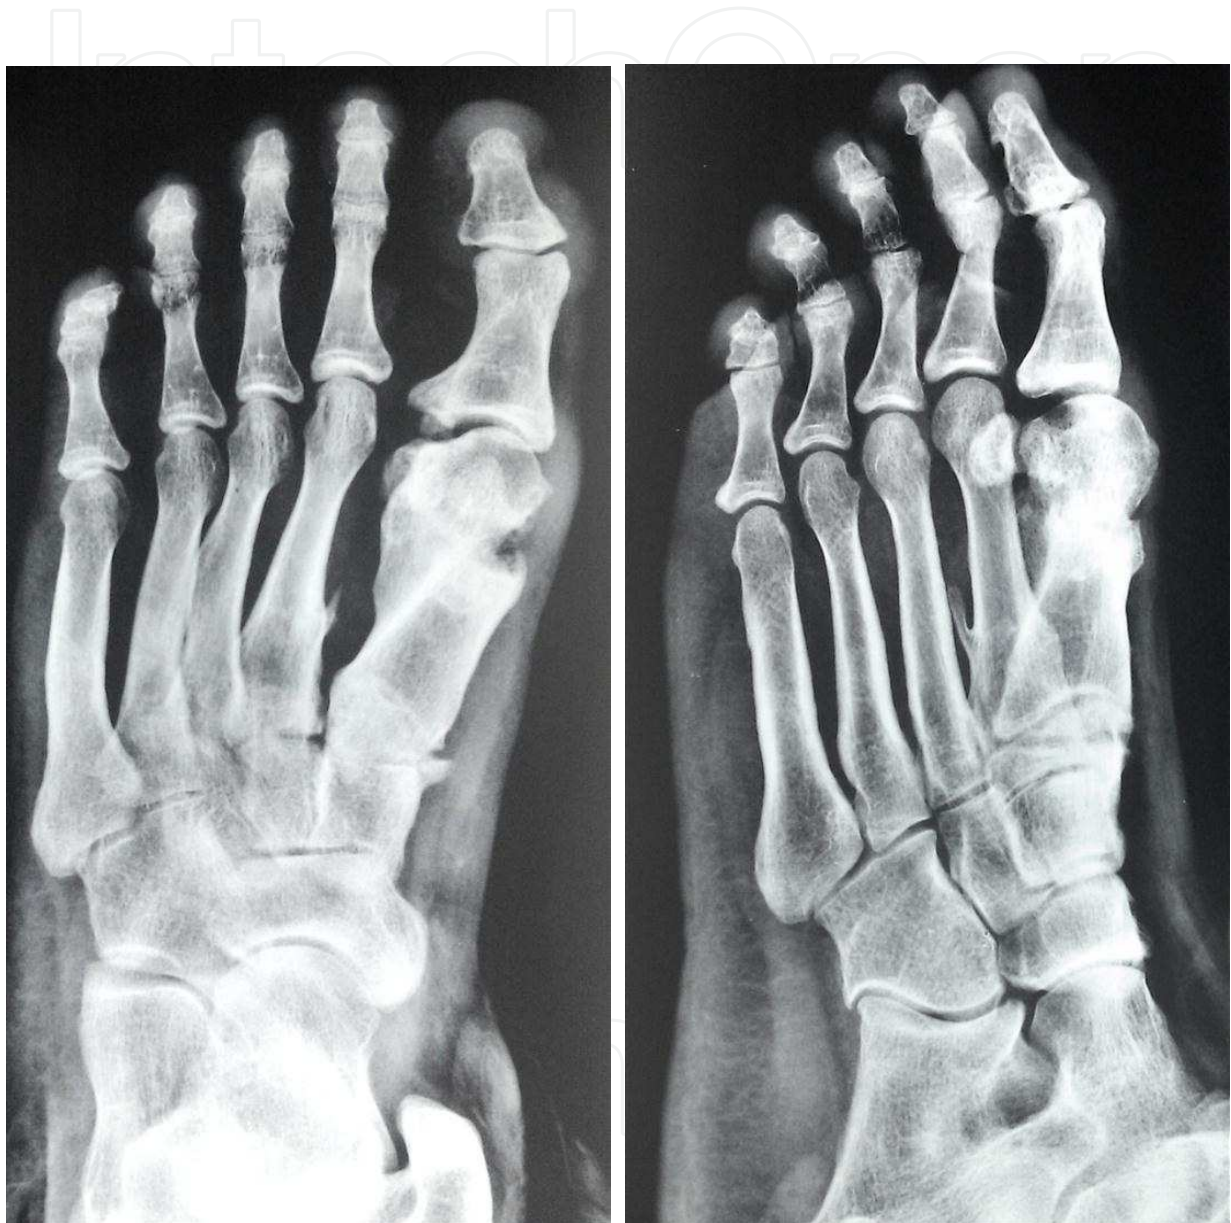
A-P and oblique standing radiograph, showing remodeling of the First MTP 24 months postoperative.
